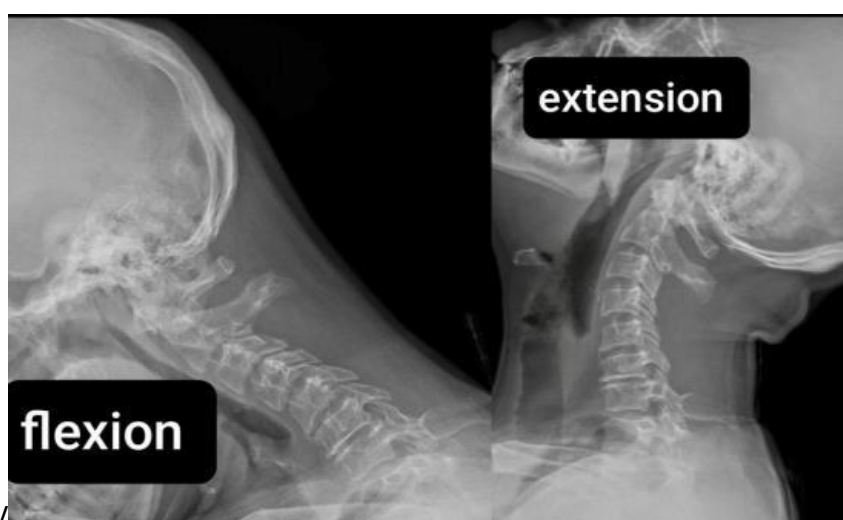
I): Lateral cervical X-ray measuring C2–C7 Cobb’s angle preoperative (A) and postoperative (B). II): MRI sagittal T2 view preoperative (left) and postoperative (right). III): MRI T2 axial view preoperative. IV): MRI T2 axial view postoperative. V): Dynamic X-ray views in flexion and extension postoperatively confirming maintained cervical stability.
